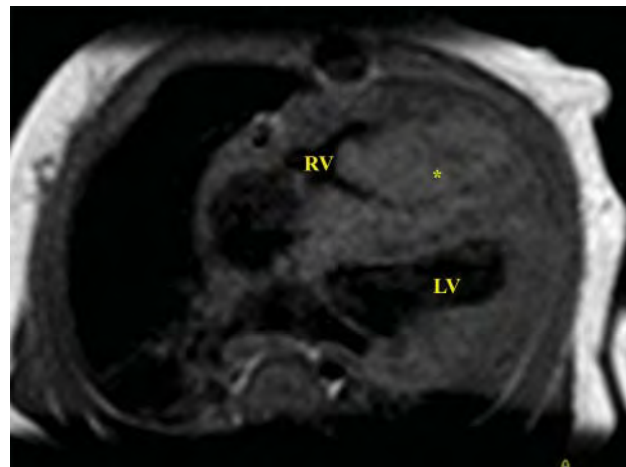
T1-weighted imaging in the four-chamber geometry of a child with a large rhabdomyoma (*) of the interventricular septum. LV, left ventricle; RV, right ventricle.
